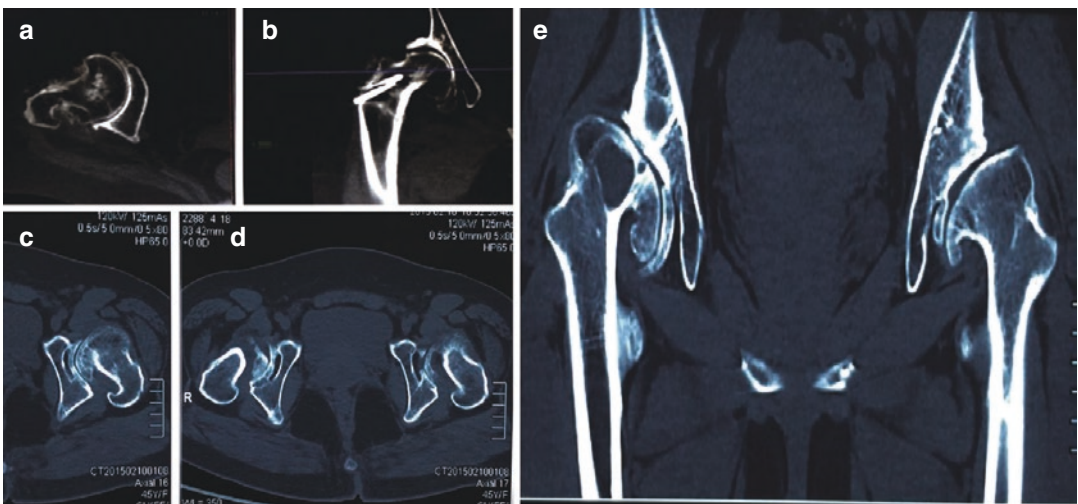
Computed tomography in developmental dysplasia of the hip. (a) This CT shows a shallow acetabulum, poor matching between the acetabulum and femoral head, a thin anterior wall, and a superior lateral defect. (b) femoral
